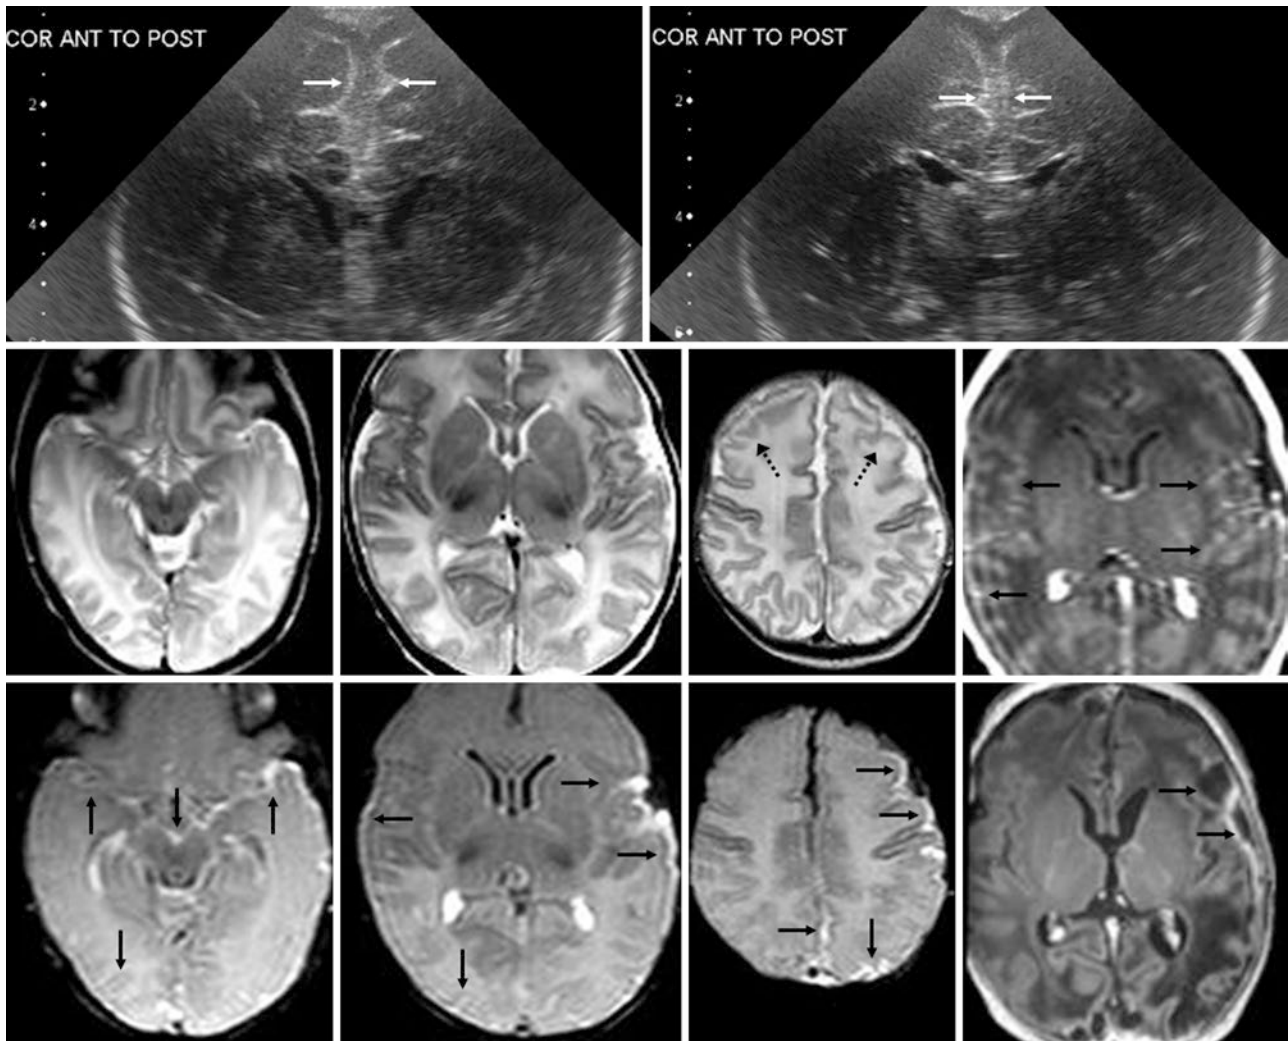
Comparison case of group B streptococcal meningitis. *Top row:* A 21-day-old term neonate with prolonged fevers and altered mental status had coronal ultrasound images that demonstrated echogenic material within the subarachnoid space (*arrows*), which was considered suspicious for exudate. A 3T MRI was ordered the next day (with contrast, given the clinical history). *Middle row:* On MRI, SE T2WI (*left three images*) showed subtle blurring of the normal cortical ribbon
